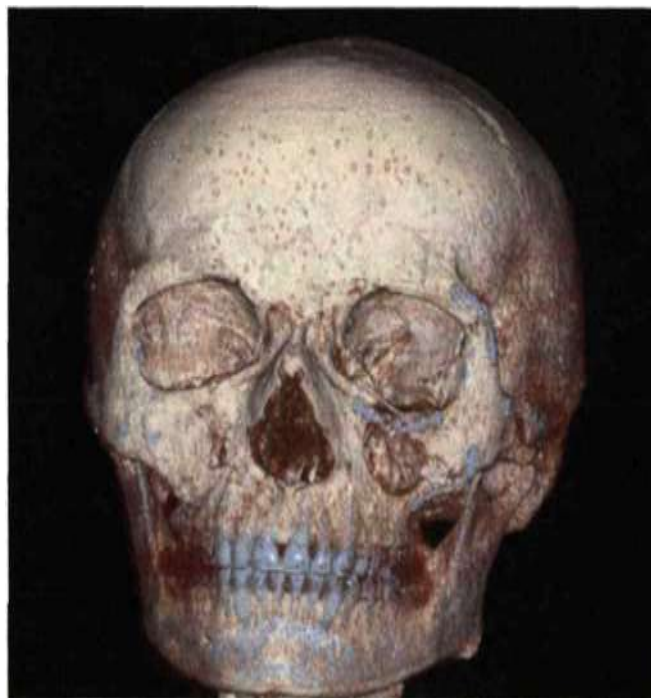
3. Computed tomography of the bones of the facial skeleton of patient V. at admission
